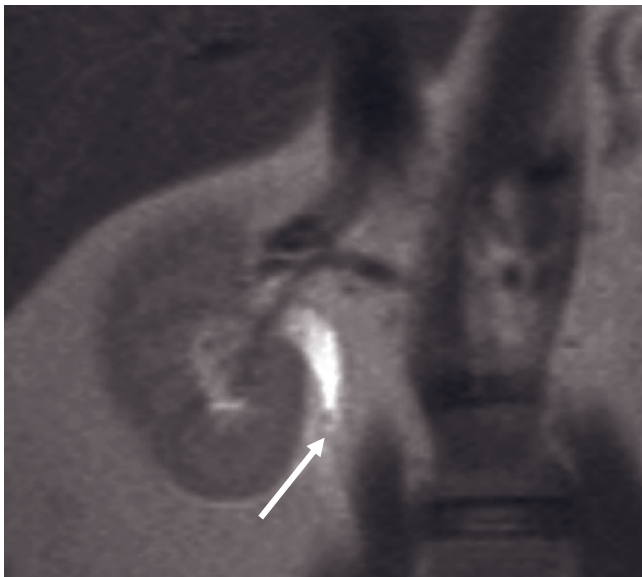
(*Continued*) is greatest on the T2-weighted image and the dilute gadolinium (high signal intensity)-enhanced image. Urine is high in signal intensity on these sequences and contrasts well with the signal-void calculus. T1-weighted immediate (*d*) and 10-min (*e*) postgadolinium images in a second patient demonstrate a small signal-void calculus, which is not apparent in gadolinium-free signal-void urine (*d*) but is well shown on late postgadolinium image (arrow, *e*) because of the high signal intensity of dilute gadolinium-containing urine. Coronal (*f*) and transverse fat-suppressed (*g*) T2-weighted SS-ETSE images in a third patient. A signal-void calculus (arrow, *f*) is present in the lower pole infundibulum of the left kidney. Hydronephrosis is also present.
